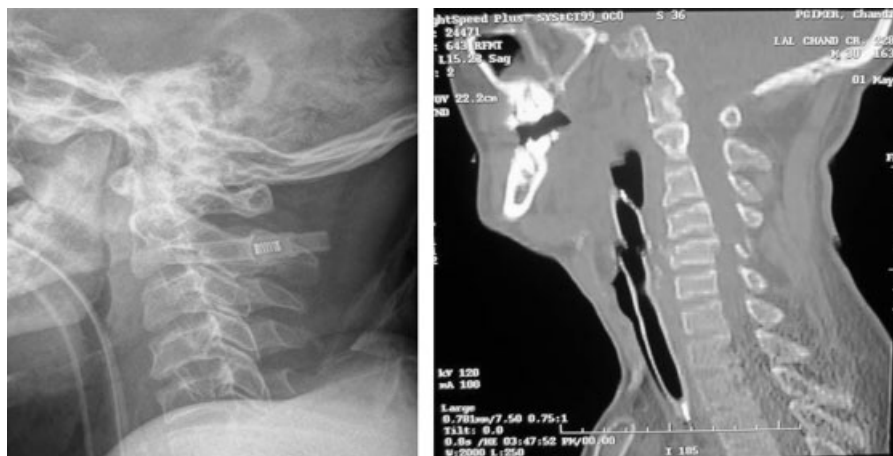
Fracture body of C5 vertebra, which was missed on plain X-ray but detected on CT scan (JPG, 960–720 pixels). CT, computed tomography.
